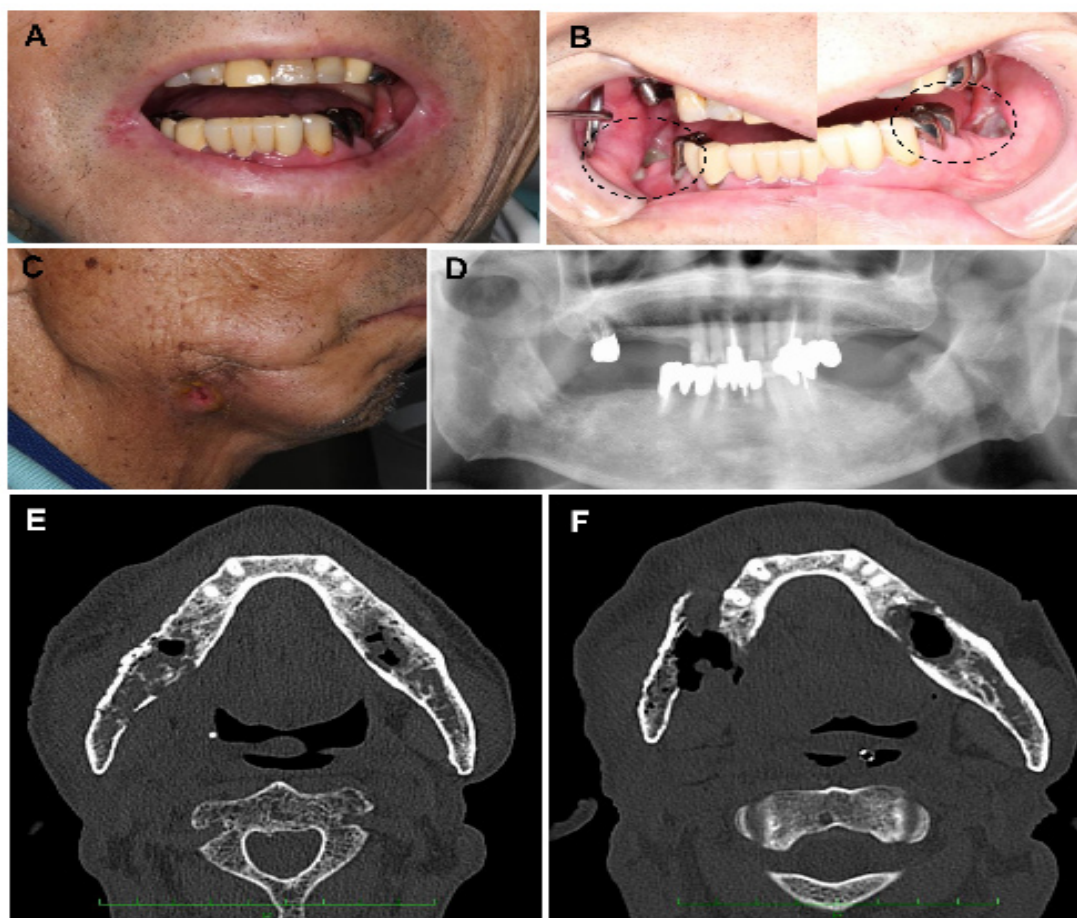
Clinical images of mandibular osteoradionecrosis. This patient received concurrent chemoradiotherapy (CCRT) (70 Gy/35 fractions and cisplatin) for left oropharyngeal carcinoma (squamous cell carcinoma, cT2N0M0). Intraoral (A, B), facial images (C), and panoramic radiography (D) at 3 years and 8 months after completion of CCRT. Note the presence of trismus (A), bilateral bone exposure in mandibular molar regions (B), and orocutaneous fistula (C). Osteolysis is more evident in computed tomography (E) than in panoramic radiography (D). The patient received repeated minimal debridement for bilateral bone exposure in the previous hospital. At 4 years after completion of CCRT, pathological fracture occurred in the right mandible (F).
